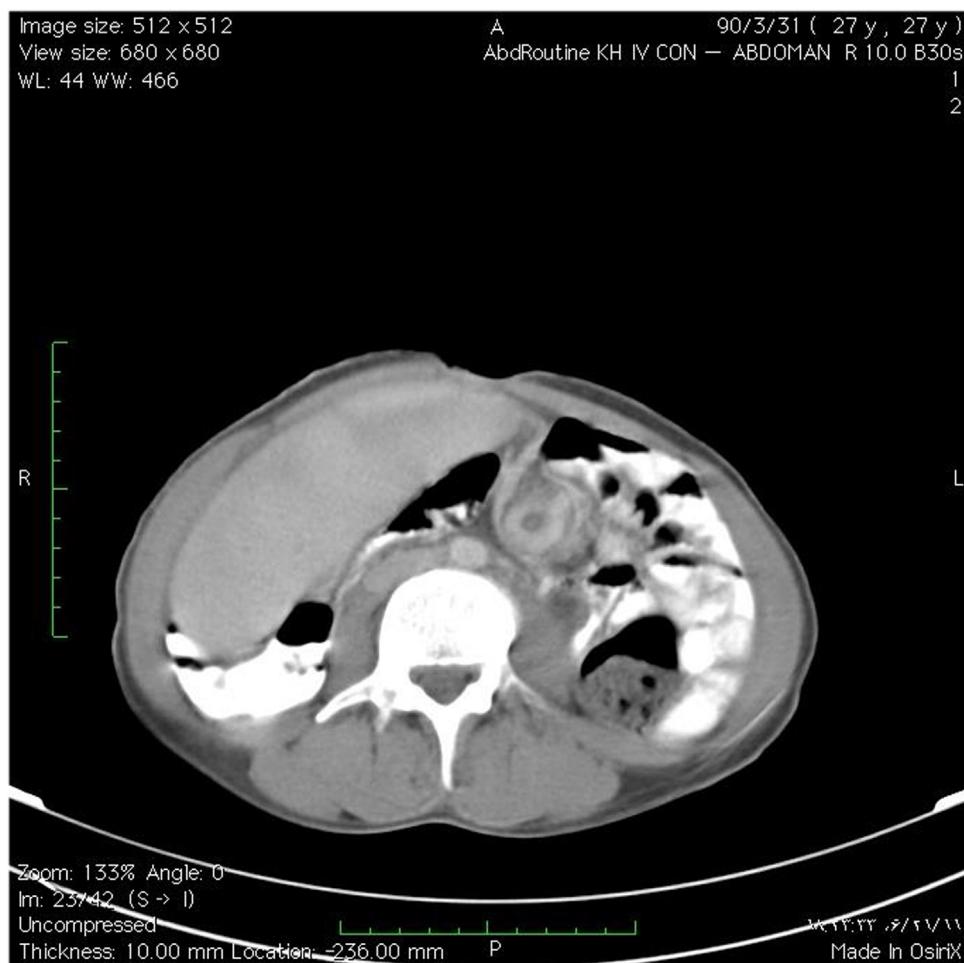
Contrast-enhanced abdomino-pelvic computed tomography (CT) showing an ectopic spleen with torsion of its pedicle.
